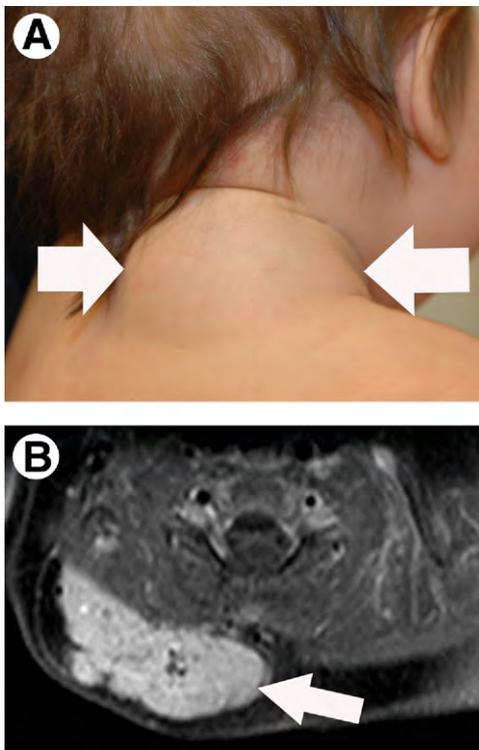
Infantile hemangioma in a 4-month-old female patient with a lump on her neck. (A) Photograph of the back of the neck shows a smooth focal lump (arrows). (B) Axial fat-suppressed T1-weighted postcontrast image reveals a well-defined vigorously enhancing mass with internal flow void located in the subcutaneous fat (arrow).
